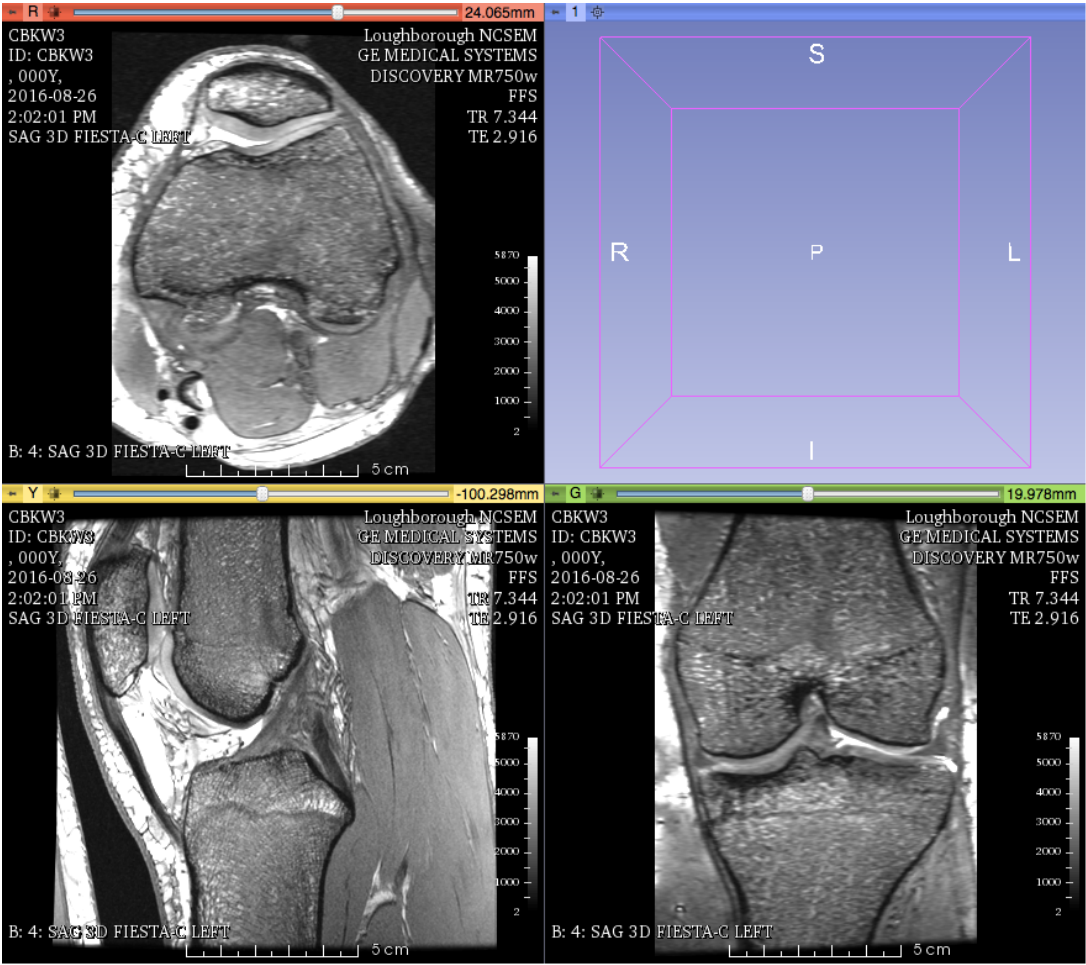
Three-plane view of a knee MRI as it appears in 3D Slicer.
